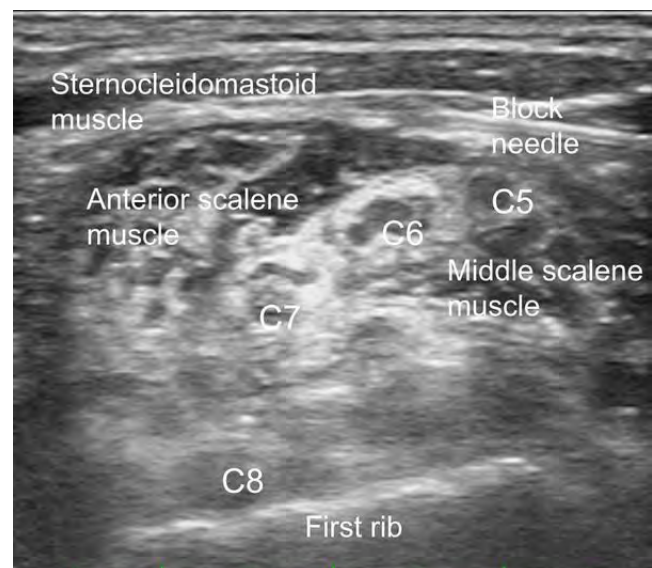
Ultrasound image taken after local anesthetic injection
